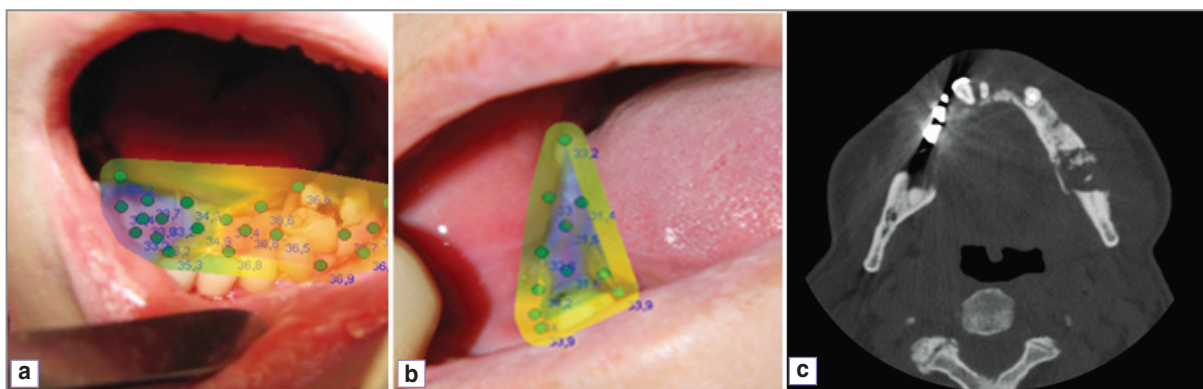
Thermograms of the acute (*a*) and chronic (*b*) phase of osteomyelitis, and computed tomogram of chronic osteomyelitis in the lower jaw on the right (*c*)
